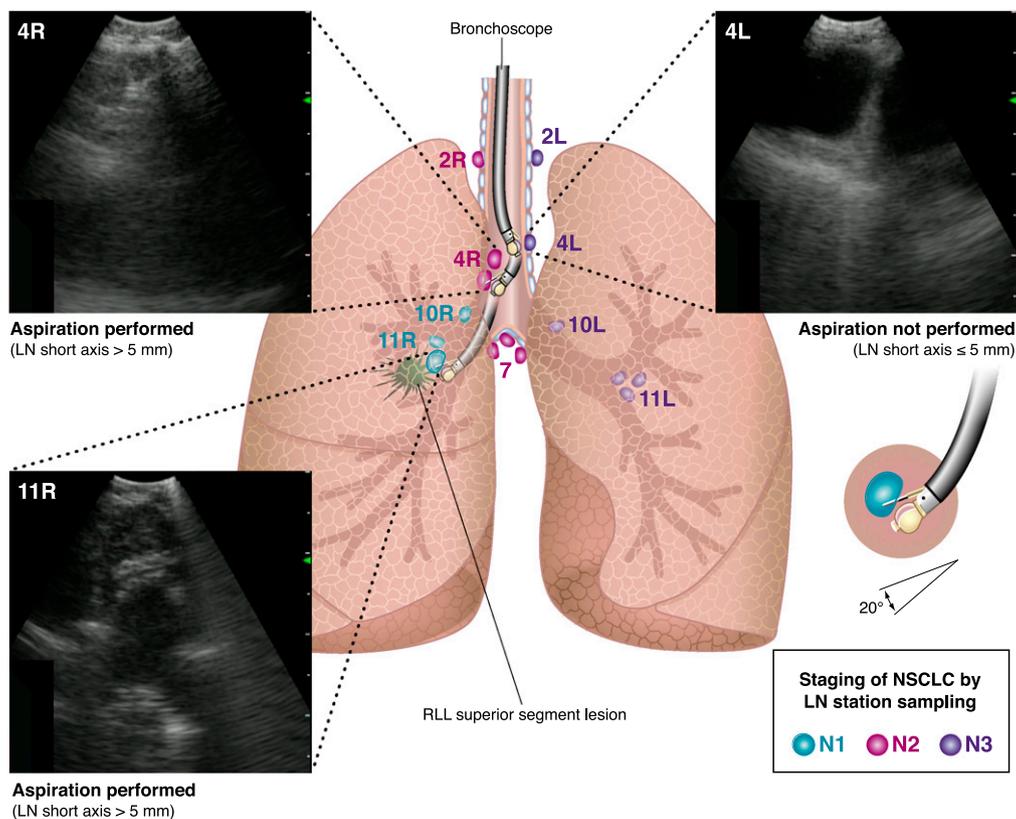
Depiction of the staging examination. The endobronchial ultrasound is first used to evaluate all N3 lymph node stations, followed by the N2 lymph node stations and the N1 lymph node stations. Representative ultrasound images are shown from three stations. At station 4R, both lymph nodes were aspirated. For clarity, the primary lesion of the right lower lobe is depicted inferior to the actual location. LN = lymph node; NSCLC = non-small cell lung cancer.
